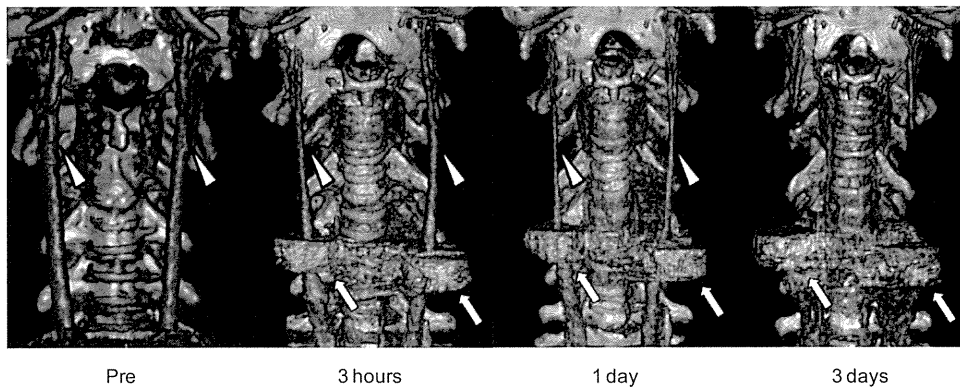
Three-dimensional volume-rendered images of computed tomography (CT)-angiography showing the blood flow of the bilateral common carotid arteries pre- and postimplantation of ameroid constrictors at indicated time intervals. Arrowheads indicate common carotid arteries and arrows ameroid constrictors.
